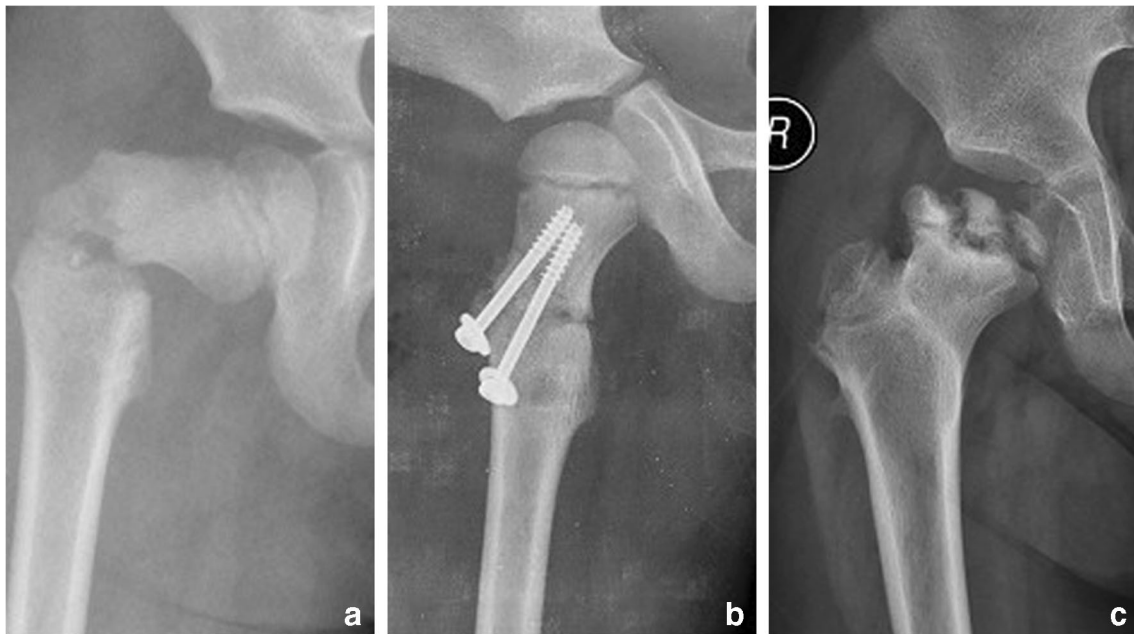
Radiographs of a 7-year-old boy with a displaced femoral neck fracture. a Anteroposterior (AP) view of a Delbet-Colonna type-III fracture, with the amount of initial angulation (A_{AP}) over 8° . b AP view
